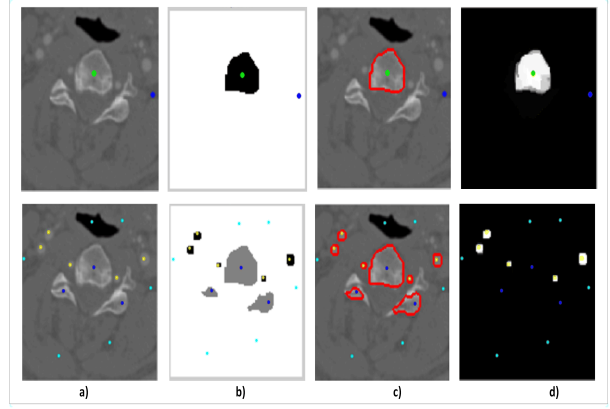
Random walk segmentation in CTA image
